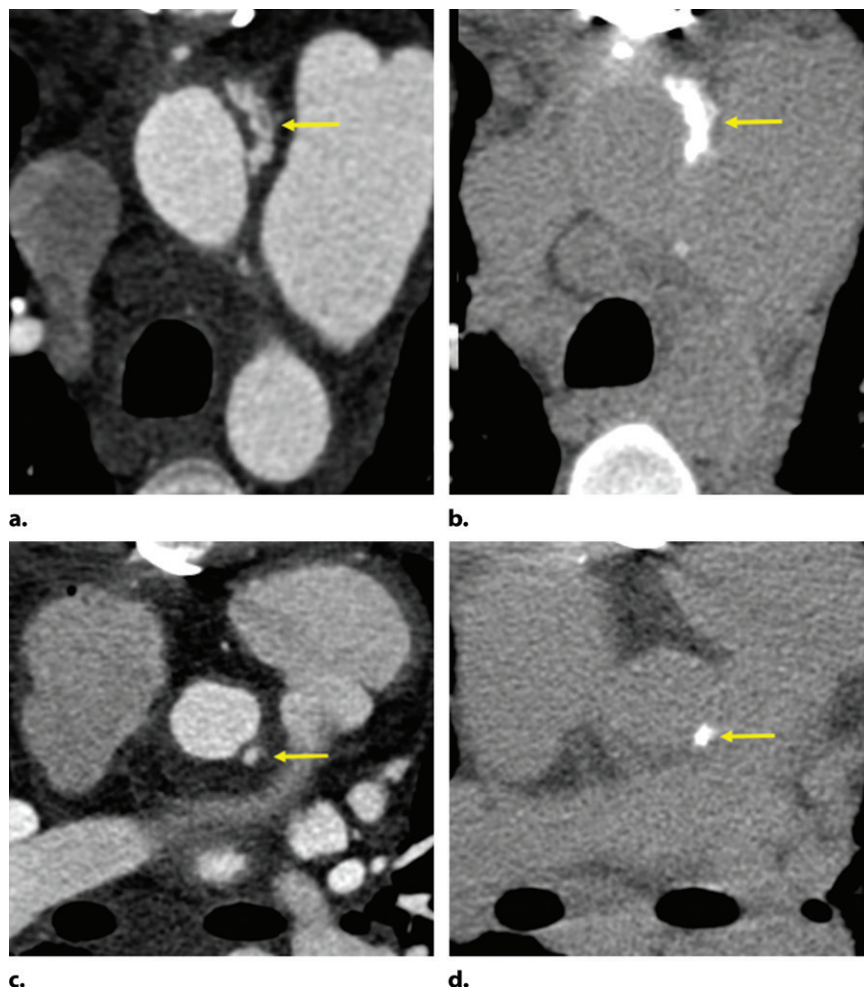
Felt pledgets in a 40-year-old woman after open surgical proximal aortic repair. (a, b) Axial contrast-enhanced (a) and noncontrast (b) CT images show a hyperattenuating structure (arrow) consistent with a felt pledget along the left anterolateral aspect of the aorta. (c, d) Axial contrast-enhanced (c) and noncontrast (d) CT images inferior to a and b show an additional pledget (arrow) along the left posterolateral aspect of the aorta. As shown here, felt pledgets can have different shapes. They are used liberally in open surgical repairs of the proximal aorta to control hemostasis, provide reinforcement, and seal off access sites. Awareness of felt pledgets prevents confusion with pseudoaneurysms. Although not typically required, noncontrast acquisitions can be used to confirm the presence of a hyperattenuating pledget.
